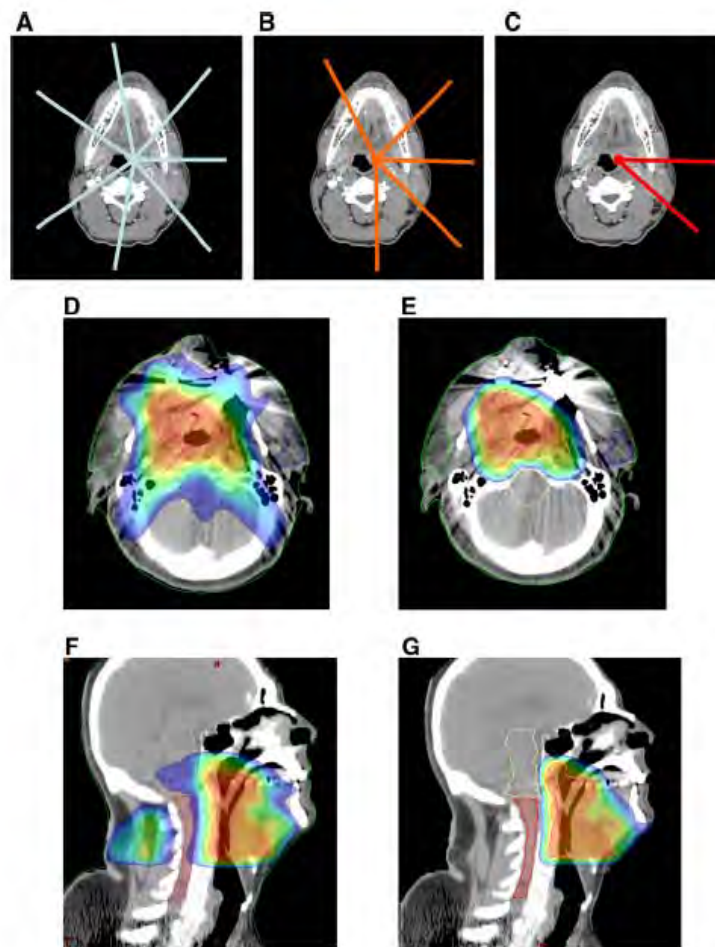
Beam arrangements and treatment planning images. Representative beam arrangements used for (A) photon plans to treat PTV₇₀ with a seven-field technique, (B) proton plans to treat PTV₅₀ and PTV₆₄ with a five-field technique, and (C) proton plans to treat PTV₇₀ with a two-field technique. Beam angles for photon plans were equally spaced and centered on each corresponding PTV. Beam angles for proton plans were individualized for each patient to minimize dose to critical structures and maintain optimal PTV coverage and dose homogeneity throughout the target volumes. Representative treatment planning images for a patient with cT4N2cM0 stage IVA squamous cell carcinoma of the oropharynx (base of tongue) in axial planes for (D) IMRT and (E) proton therapy, and in sagittal planes for (F) IMRT and (G) proton therapy. Images depict treatment to PTV₇₀, the final treatment conedown targeting gross disease with margin. The same slices from the same initial CT data set were employed for Fig. 1D and E and Fig. 1F and G. Color coding: red = 100% to blue = 50% of 6 Gy in 2 Gy fractions.
